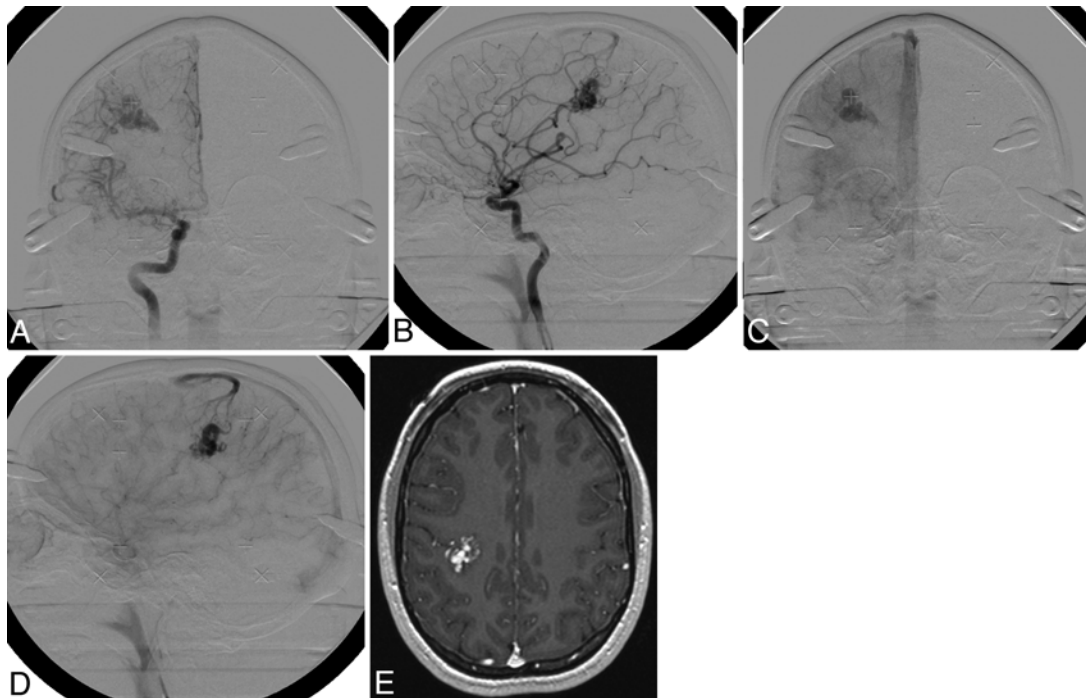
Digital subtraction angiography and MRI of the AVM of the right central sulcus prior to GKS. Digital subtraction angiography is shown with right internal carotid artery injection in anteroposterior (B and D) and lateral projections (A and C) in the arterial phase (A and B) and capillary phase (C and D), demonstrating shunting in the middle cerebral artery territory and an early draining vein into the superior sagittal sinus. In addition, a stereotactic, axial T1-weighted MR image obtained after Gd administration (E) demonstrated a contrast-enhancing vascular lesion consistent with an AVM in the region of the central sulcus.
